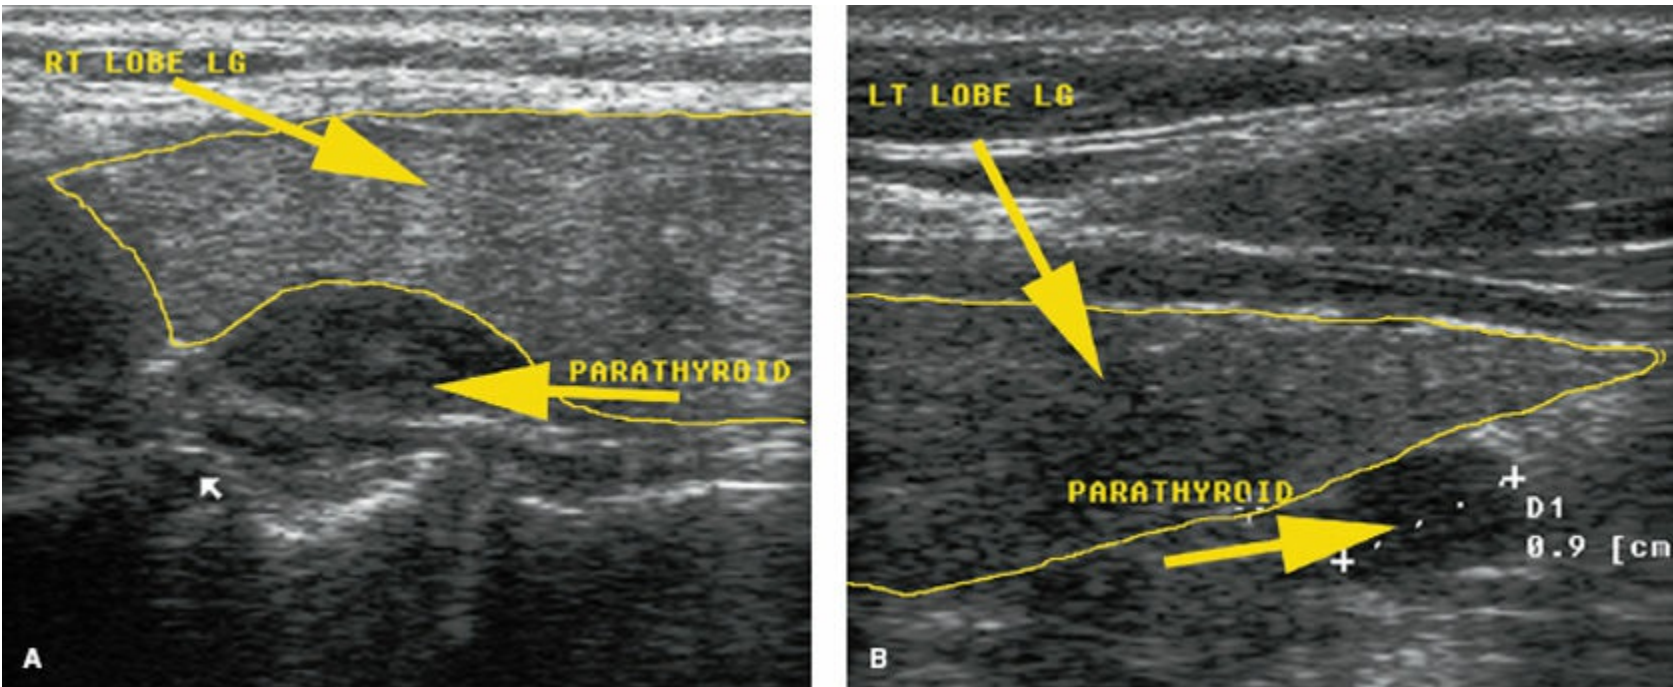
Ultrasound views of parathyroid adenomas. A: Sagittal image of the upper pole of the right lobe of the thyroid gland, demonstrating a hypoechoic parathyroid adenoma posterior to the thyroid parenchyma. B: Sagittal image of the lower pole of the left lobe of the thyroid gland with an adjacent hypoechoic parathyroid adenoma measuring 9 mm in greatest dimension.
